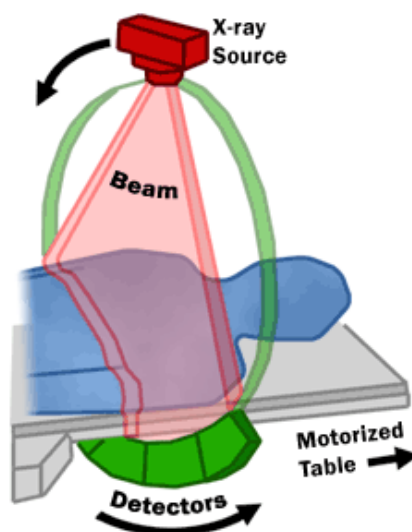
CT fan beam and patient in a CT imaging system.⁶⁰
